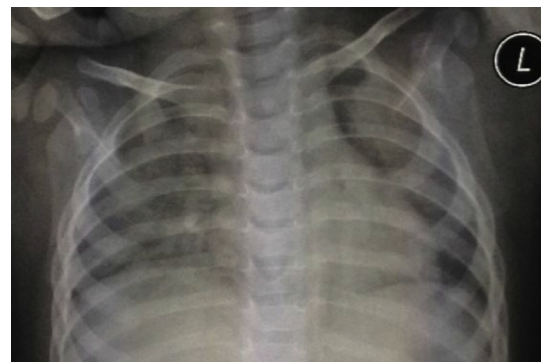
Wide lesions type in a 28-month-old boy with severe HFMD. This chest X-ray shows diffuse cloud floccule in both lung fields.
